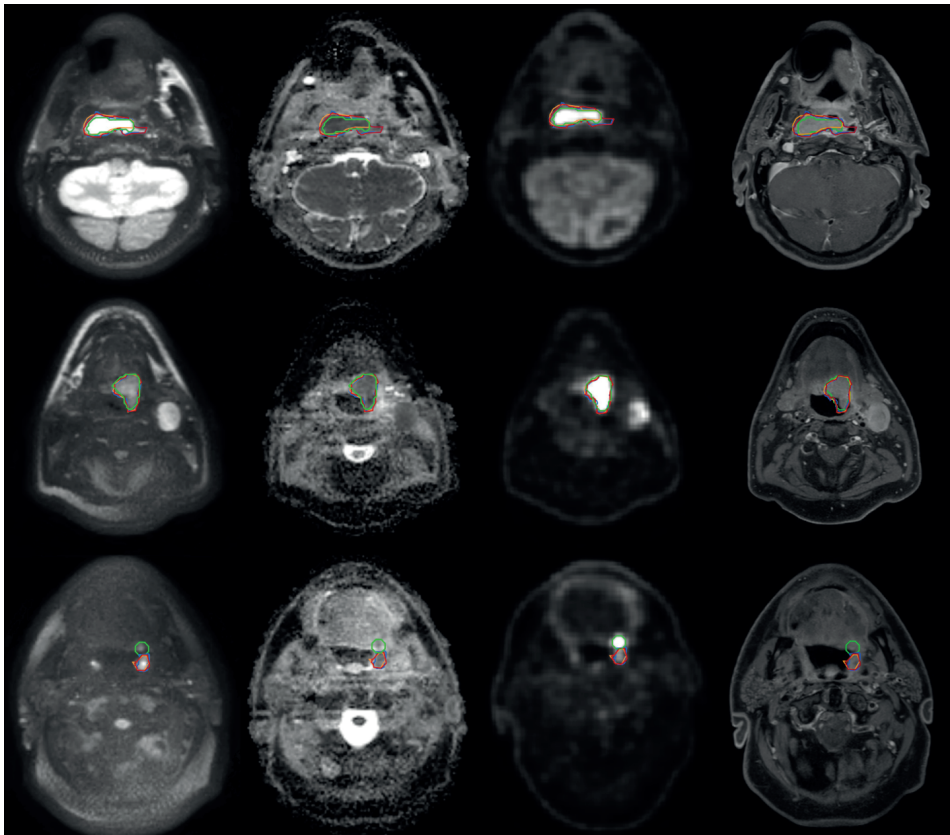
Patient examples showing the correspondence of the delineated target volumes. Each row of images is from a single patient and shows transverse slices with, from left to right: DW b800; ADC map; FDG-PET; T1 weighted TSE mDixon water reconstruction after gadolinium contrast agent injection. The images are taken from patient 9, 12 and 1 respectively. The delineations from FDG-PET (green), DW_1 (red), DW_2 (blue) and DW_3 (orange) are shown on all imaging.
